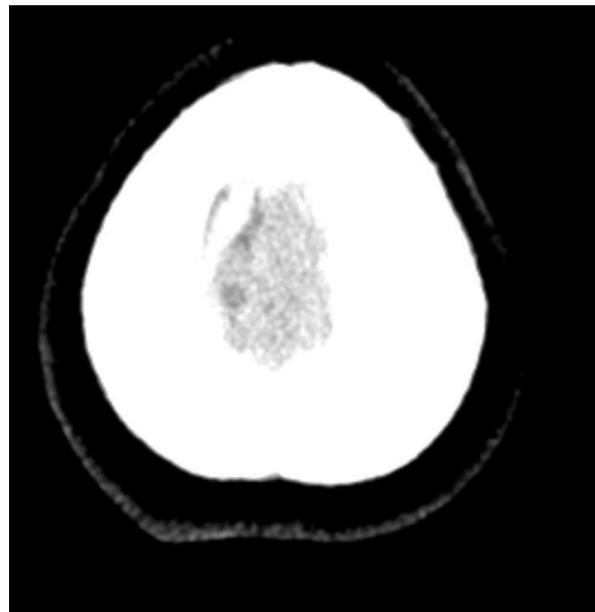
Axial CT showing Superior Cerebral Vein Thrombosis.
